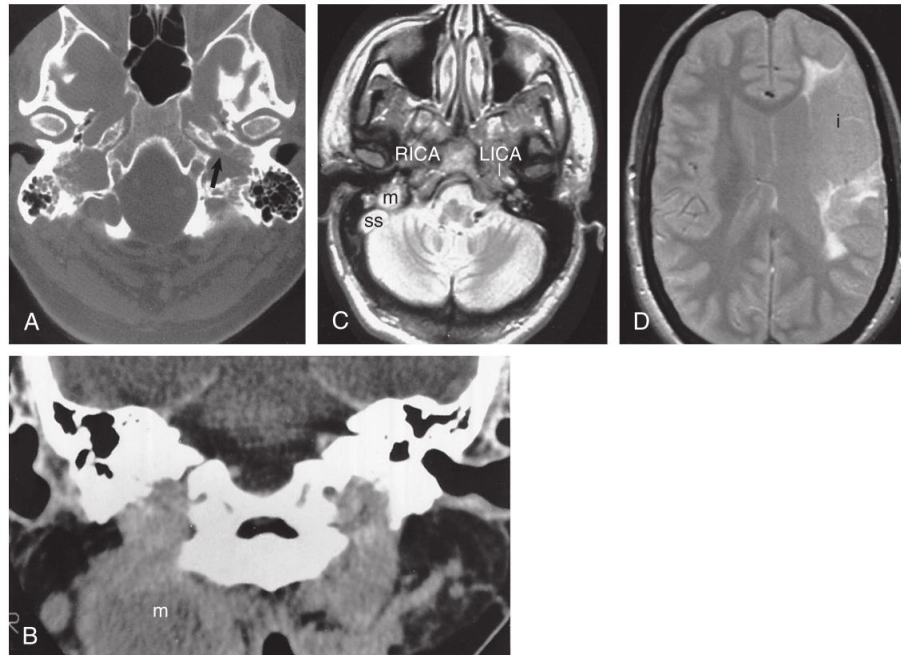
Familial paragangliomas in a 53-year-old woman. The tumors included bilateral glomus jugulare paragangliomas, a right-sided glomus vagale paraganglioma, and bilateral carotid body paragangliomas. A, Axial view, computed tomography (CT), bone algorithm. This CT study is performed with a small field of view and a bone algorithm to increase the resolution of bone edges. The bilateral glomus jugulare paragangliomas are destroying bone from the pars vasculosa laterally. On the left side, the lesion is destroying the septum between the internal carotid artery and the internal jugular vein—common findings in a glomus jugulare paraganglioma (*arrow*). B, Coronal view, CT with intravenous contrast. Both glomus jugulare paragangliomas extend into the neck. However, another large mass can be seen on the right, a glomus vagale paraganglioma (*m*). C, Axial view, T2-weighted magnetic resonance imaging (MRI). The high-signal-intensity lesion, a glomus jugulare paraganglioma (*m*), has occluded the sigmoid sinus, which shows high-intensity signal (*ss*). The left internal carotid artery (*LICA*) shows signal of pathologic high intensity. This vessel has been occluded by a large paraganglioma in the neck (*not shown*). Compare the signal intensity of this vessel with the normal dark black appearance of internal carotid artery flow on the right (*RICA*). Although MRI cannot provide the fine bony resolution of CT (see B), it gives more information about vascular patency. D, The *LICA* occlusion has resulted in a middle cerebral arterial distribution infarct (*i*).
